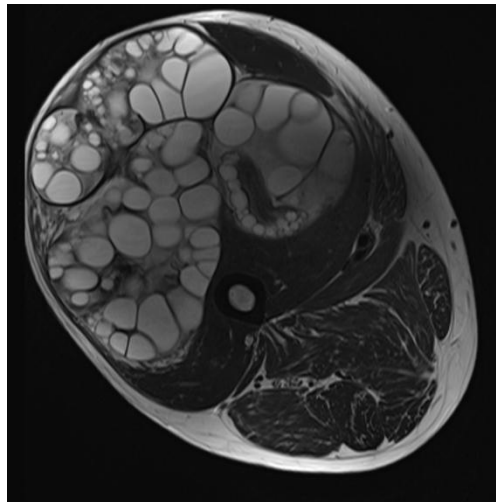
axial T2 MRI images with characteristic appearance of multiple daughter cysts within the mother cyst.
